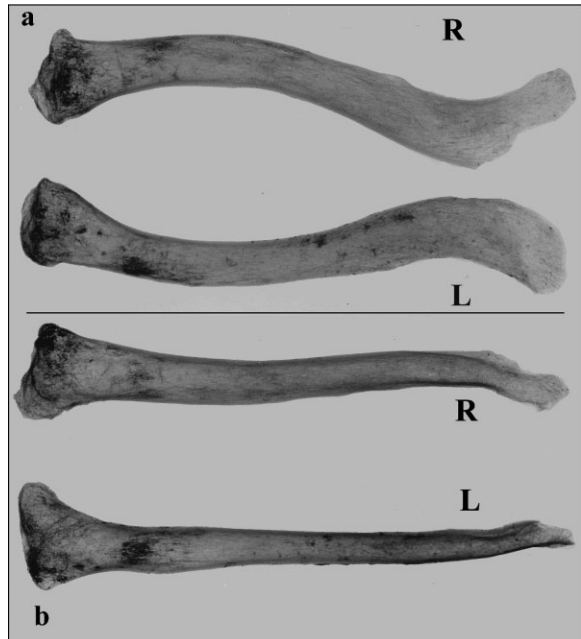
(a) Superior-inferior and (b) anterior-posterior radiographs of right and left clavicles.
